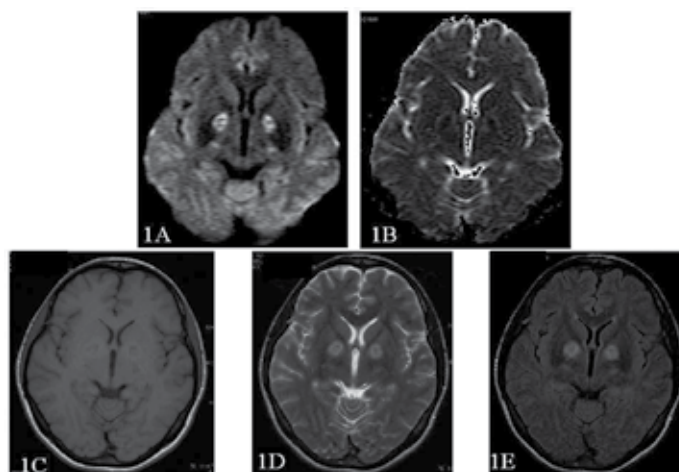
Magnetic resonance imaging study in the acute stage of carbon monoxide intoxication.
